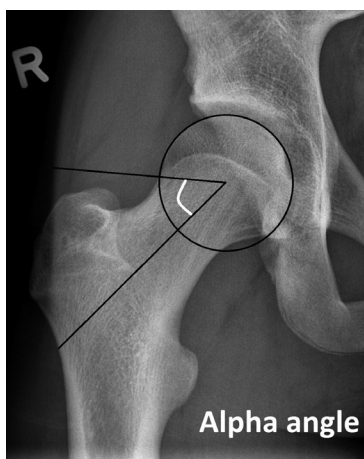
Alpha angle measurement on an anteroposterior X-ray of the hip joint (white angle)
